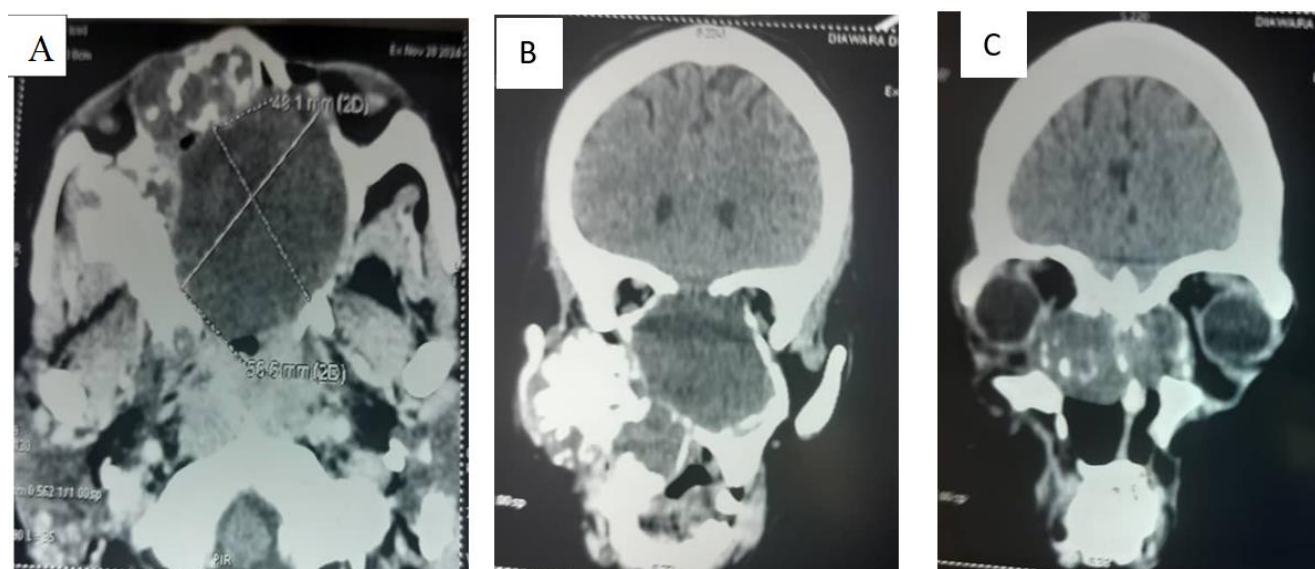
CT images A. axial section: mass of tissue density taking the ethmoid cells and the 2 sphenoidal sinuses B. coronal section: mass of tissue density taking the two nasal cavities, the maxillary sinuses, the ethmoid cells C. Coronal section: showing microcalcifications in the root ball.
